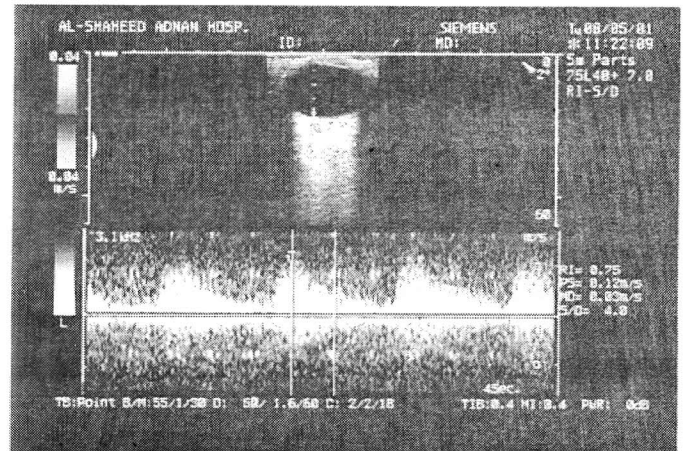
Central retinal artery (Abnormal Pulsated Doppler waveform).
